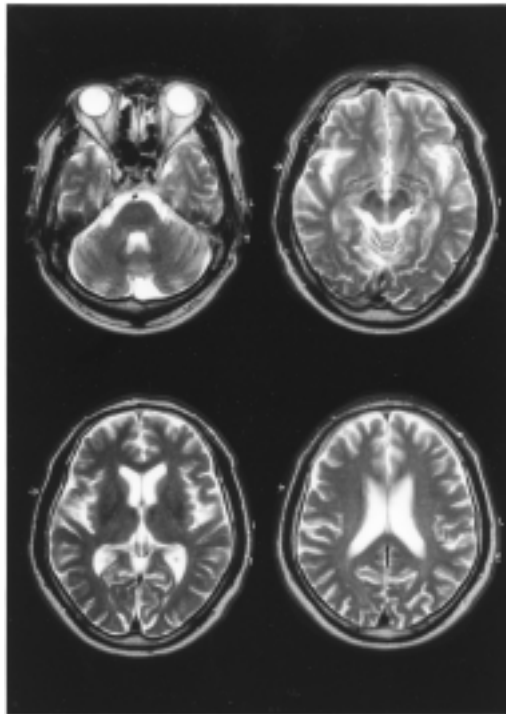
Cranial MRI examination. T₂-weighted image of MRI performed on attack day shows no particular abnormal findings.
